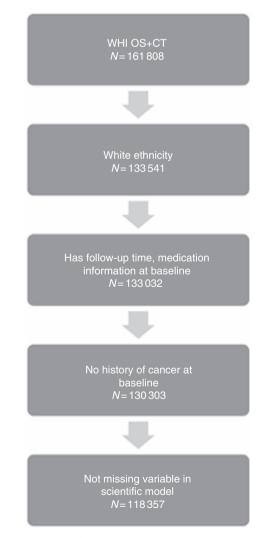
Sample size for WHI OS + CT analytic cohort.
